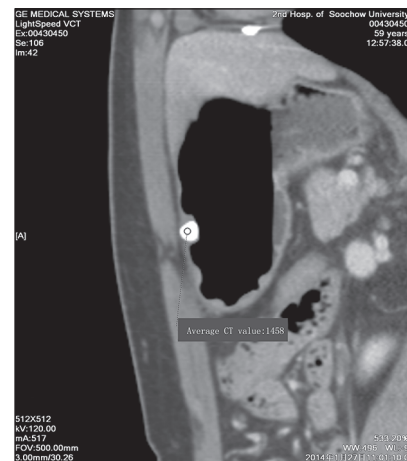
Computed tomography revealed a quasi-circular dense shadow originating from the gastric wall, indicating the presence of a calcification
